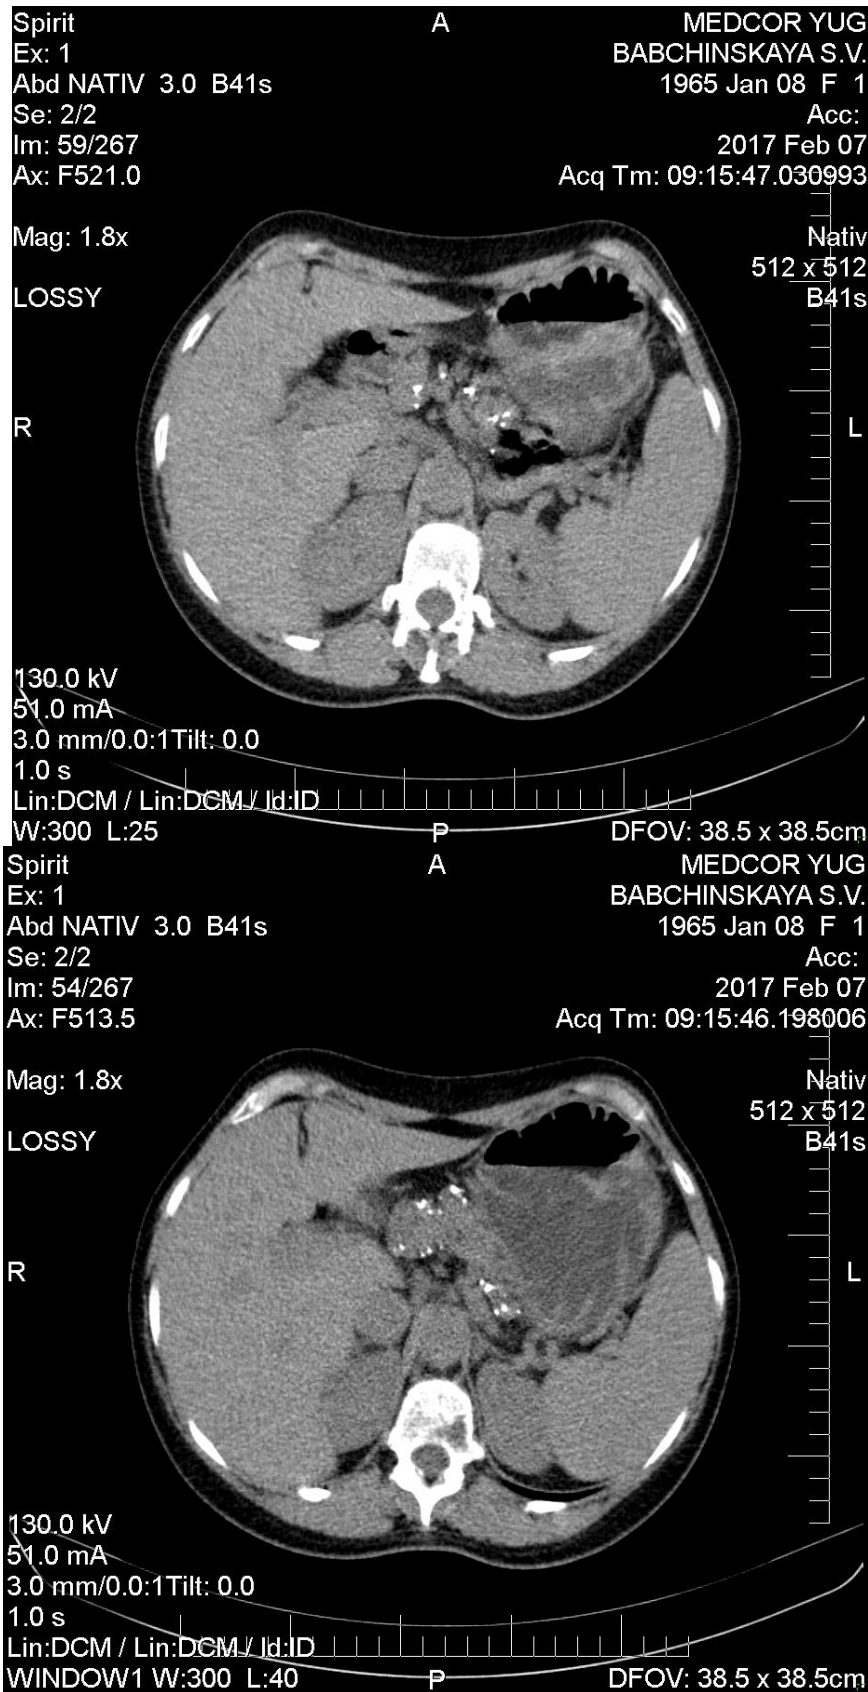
CT of the abdomen and retroperitoneum patient B. (without counterstain as Nia due to the presence in the patient CRF) (explanation in the text).
